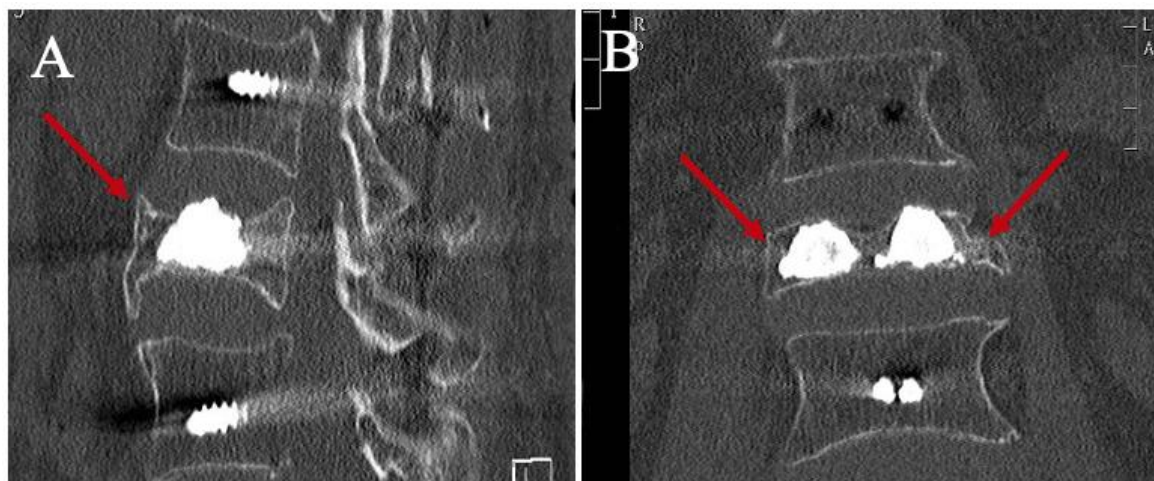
Case 6. (A) Postoperative sagittal and (B) coronal reconstructed CT scans of A.3.3 fracture (red arrows)
